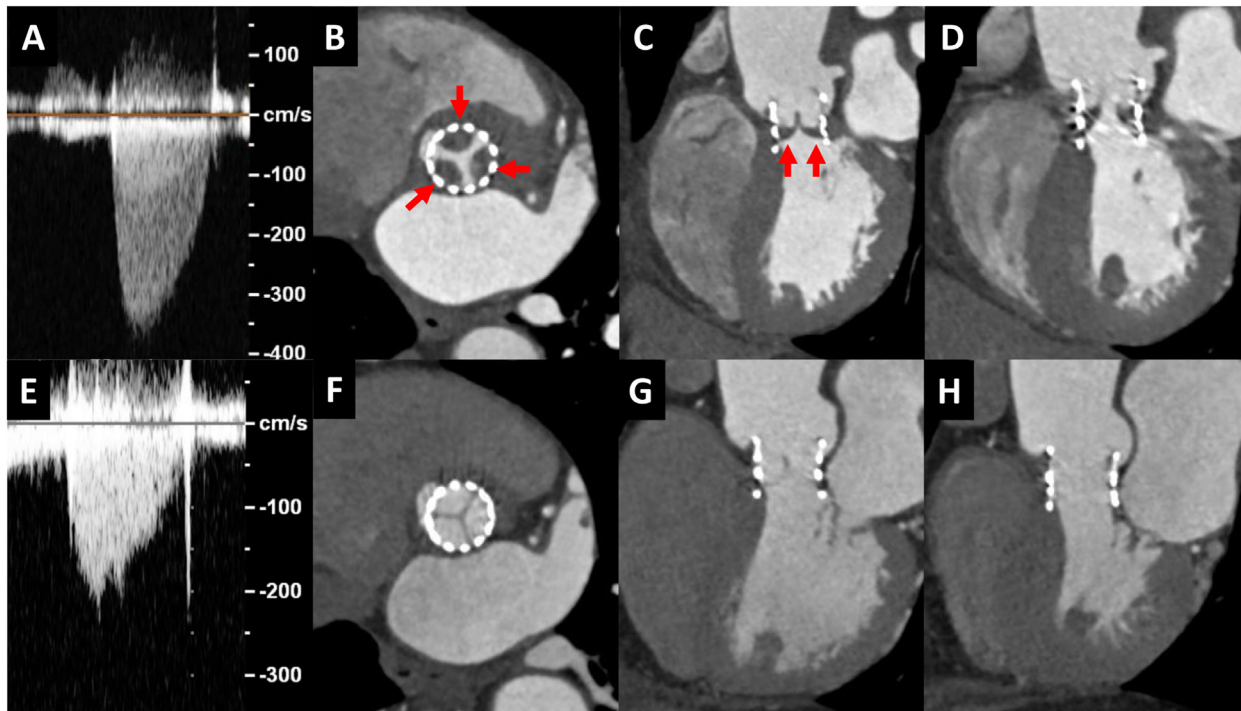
(Panel A) Increased mean gradient (28 mm Hg) and peak velocity of 3.6 m/sec across a 23-mm SAPIEN 3 valve were noted approximately 4 months following TAVI. Cardiac CT demonstrated hypoattenuated leaflet thickening (HALT; red arrows) with 50% to 75% leaflet involvement (B, C) and hypoattenuation affecting motion (D). After initiation of anticoagulation, mean gradient decreased to 14 mm Hg (E). Repeat cardiac CT demonstrated resolution of HALT (F, G) with normal leaflet mobility (H).
